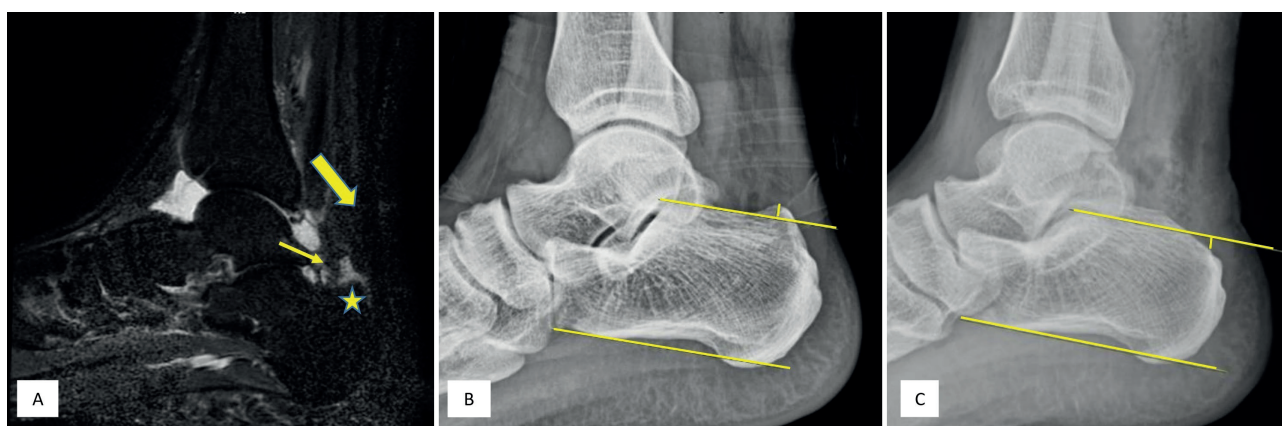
(A) MRI image of a Haglund deformity. The star indicates a bony prominence, the thin arrow indicates retrocalcaneal bursitis, and the thick arrow indicates the Achilles tendon. (B) and (C) The parallel pitch line consists of two parallel lines (yellow lines), the lower line running from the inferior calcaneal tuberosity to the anterior calcaneal tubercle and the upper line running parallel to the lower line from the posterior lip of the talocalcaneal articular facet. The length of the perpendicular line drawn from the highest point of the bony prominence to the upper line was measured as the "length of the bony prominence". The measurements are shown in (B) pre-operatively and (C) post-operative.
